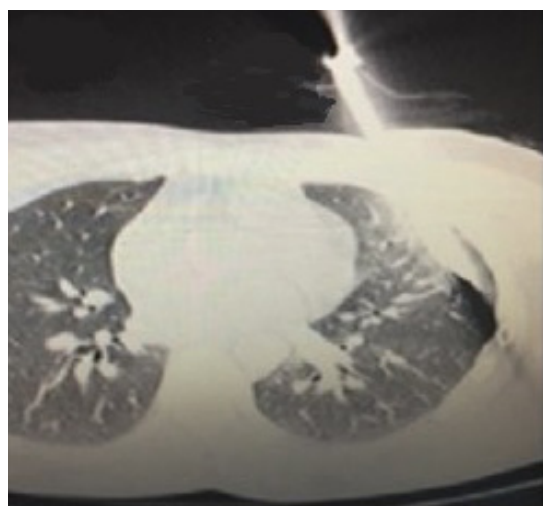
Thorax CT showing the trace of the dagger in the left hemithorax
